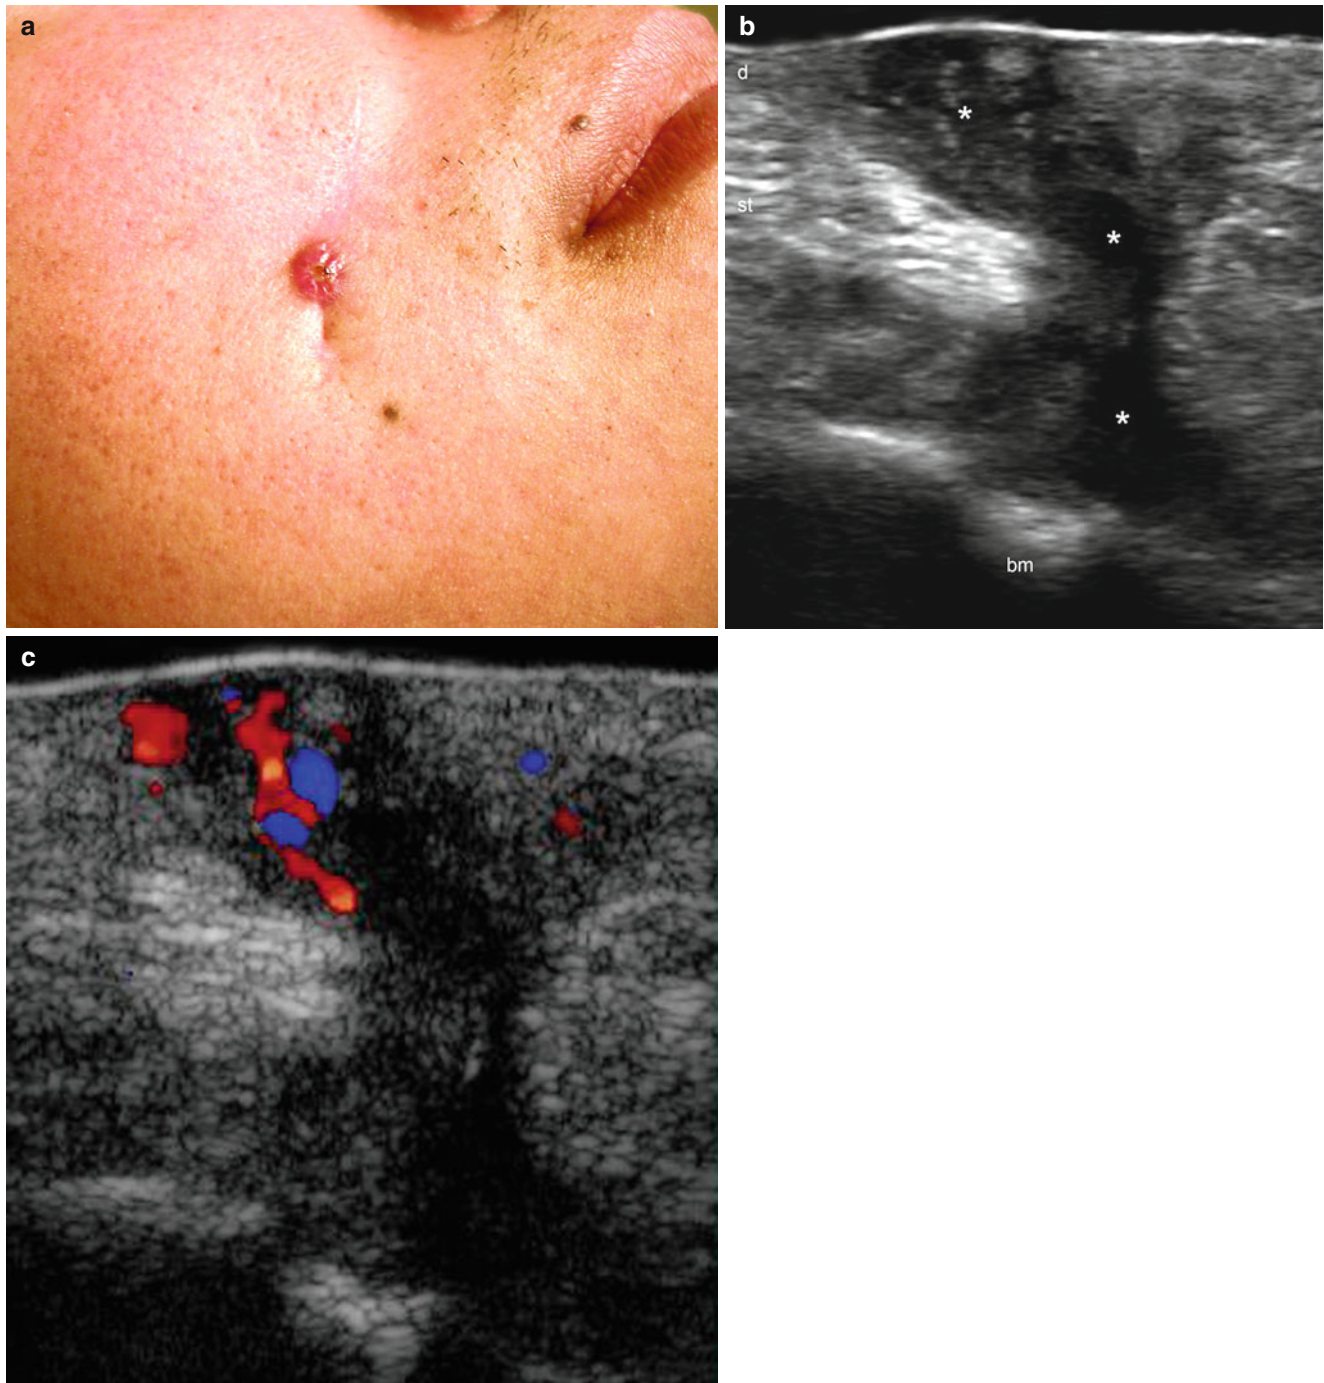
(a–c) Odontogenic fistula. (a) Clinical lesion shows erythematous papule in the right cheek. (b) Gray scale ultrasound image (oblique longitudinal view) demonstrates tortuous hypoechoic fistulous tract (*) that connects the dermis and subcutaneous tissue with the bony
